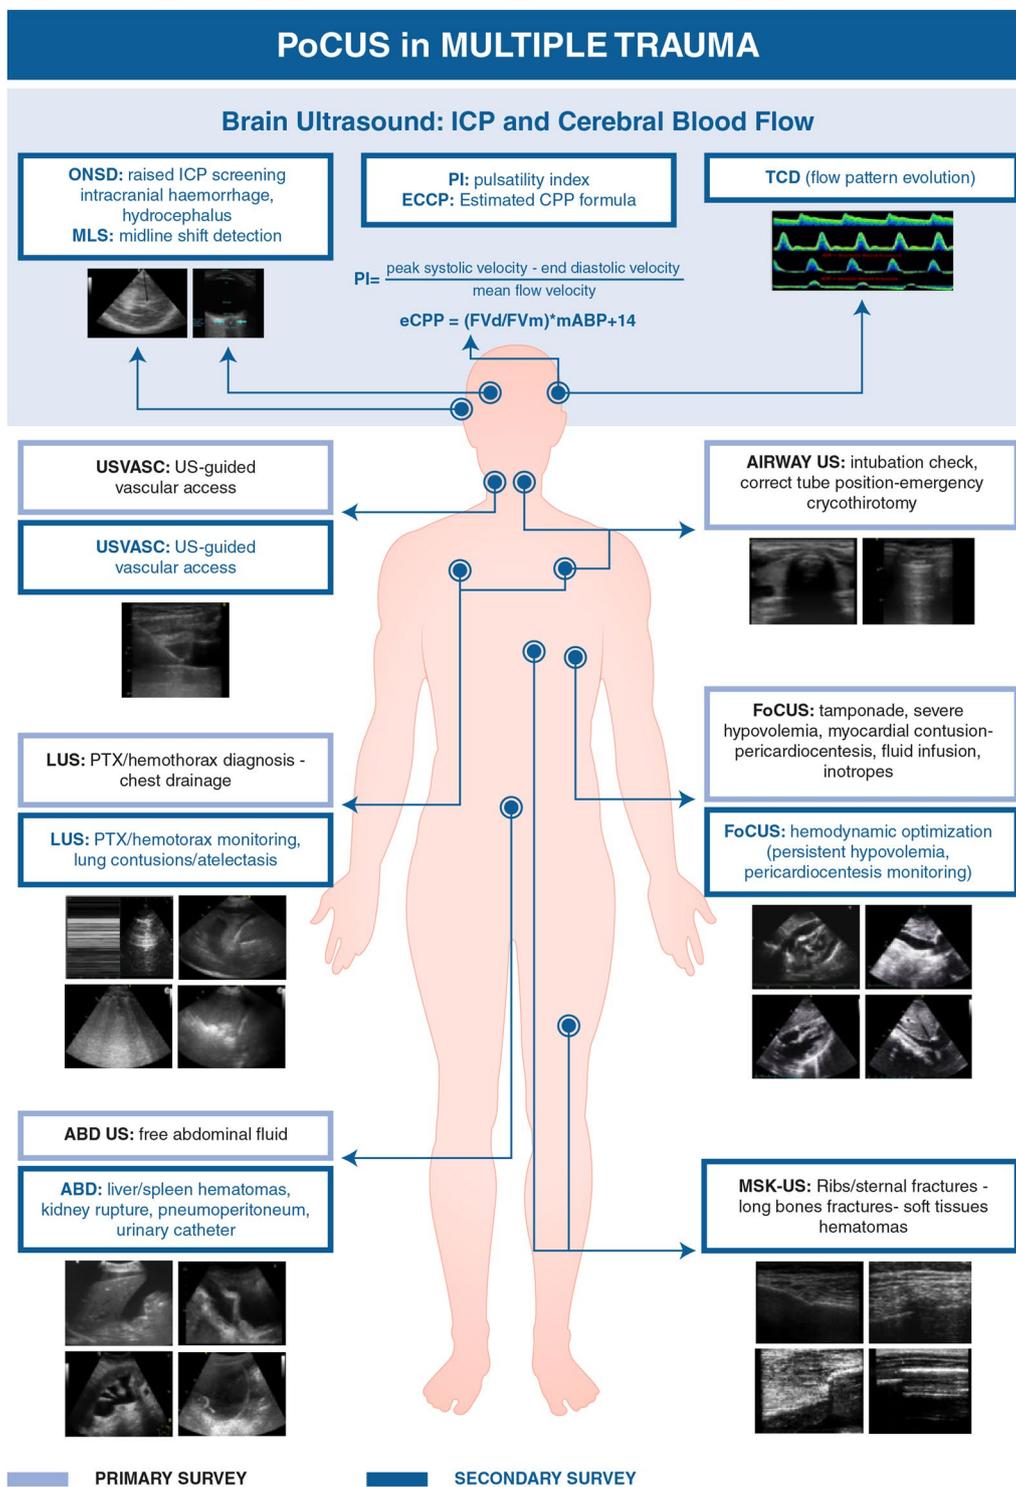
Brain ultrasonography for the assessment of multi-system trauma. Implementation of brain ultrasonography in the context of extended focused assessment with sonography in trauma (E-FAST) in the emergency room for multi-system trauma patients, as part of both the primary and the secondary survey. Brain ultrasonography (using optic nerve sheath diameter measurement and either TCD or TCCD) can be applied for the non-invasive assessment of ICP and cerebral perfusion pressure, and for the assessment of flow patterns suggesting increased ICP, as well as for the assessment of brain anatomy, including the identification of midline shift and intracranial haemorrhage
